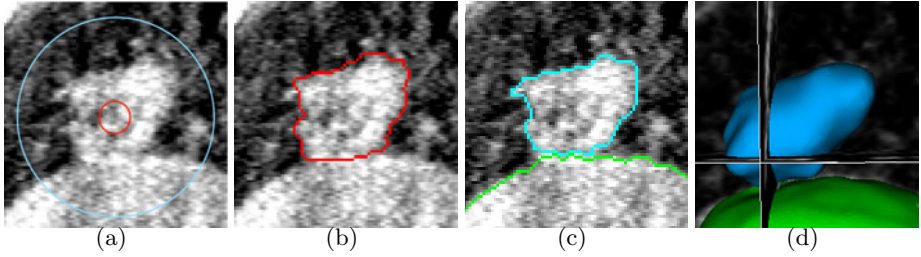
Typical tumor segmentation examples. (a) one 2-D slice of 3-D MVCBCT image with outlines of spherical initialization. (b) Manual segmentation of the lung tumor – independent standard. (c) Simultaneous region-and-surface segmentation of the diaphragm (green) and the lung tumor (blue) using our new approach showing excellent segmentation performance – $DSC = 0.878$. (d) The 3-D representation of the diaphragm (green) and the tumor (blue).
